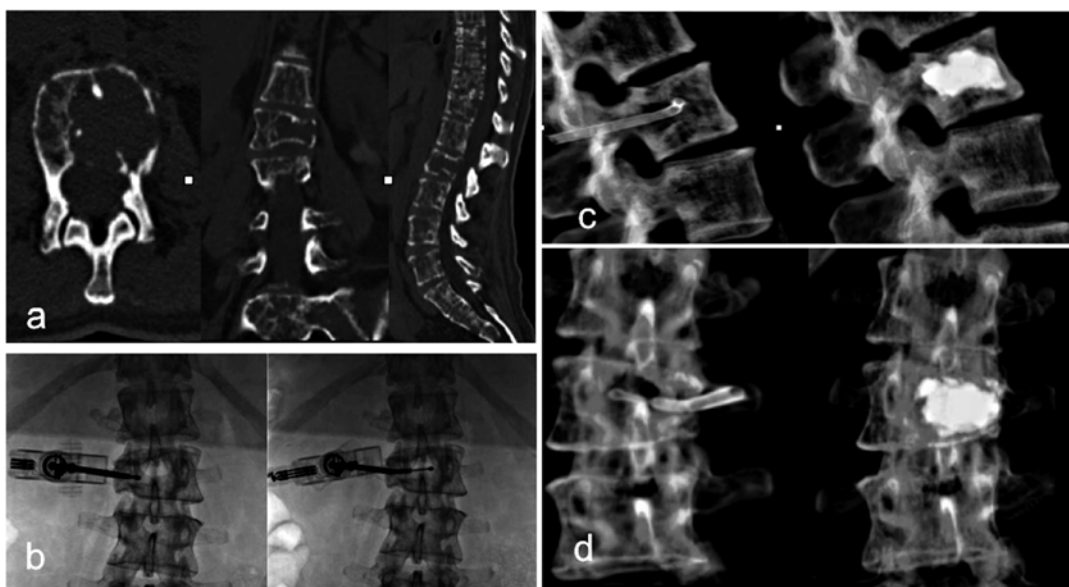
47-year-old female with multiple myeloma with L2 compression fracture. (a) Axial, coronal, and sagittal CT images demonstrating lytic L2 lesion. (b) Dfine STAR RFA instrument via left unipedicular access of L2 with tip
